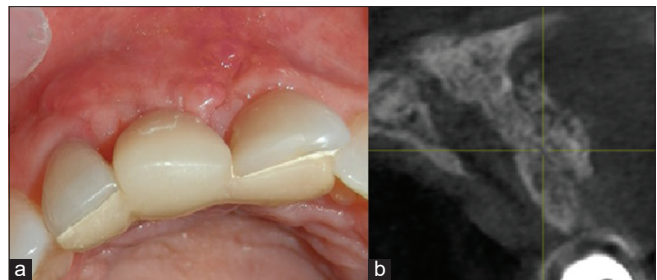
(a) Vestibular view of healing after 6 weeks of surgery. A good tissue volume can be noted. Good color and absence of signs of inflammation. (b) cone beam scan showed excellent bone regeneration after 3 months
